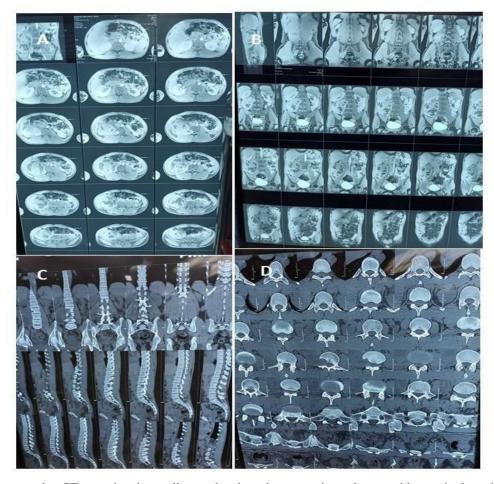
Preoperative CT scan showing well-capsulated cystic retroperitoneal mass with vertebral erosion.
